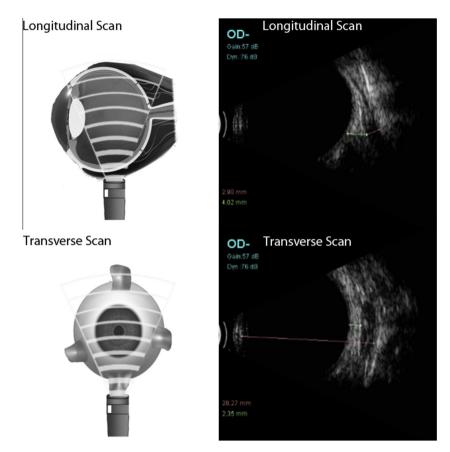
Ultrasonic images of extraocular muscles in two different probe orientations. Muscle appears fusiform shaped when the probe is directly perpendicular to the muscle in longitudinal scan (top) and muscle looks oval shaped in transverse orientation when probe is parallel to the muscle (bottom). A perpendicular line (green line) was drawn on the globe to the muscle belly and measurements were taken at 4 mm distance from the globe plane at the muscle belly before muscle thickness measurement.
